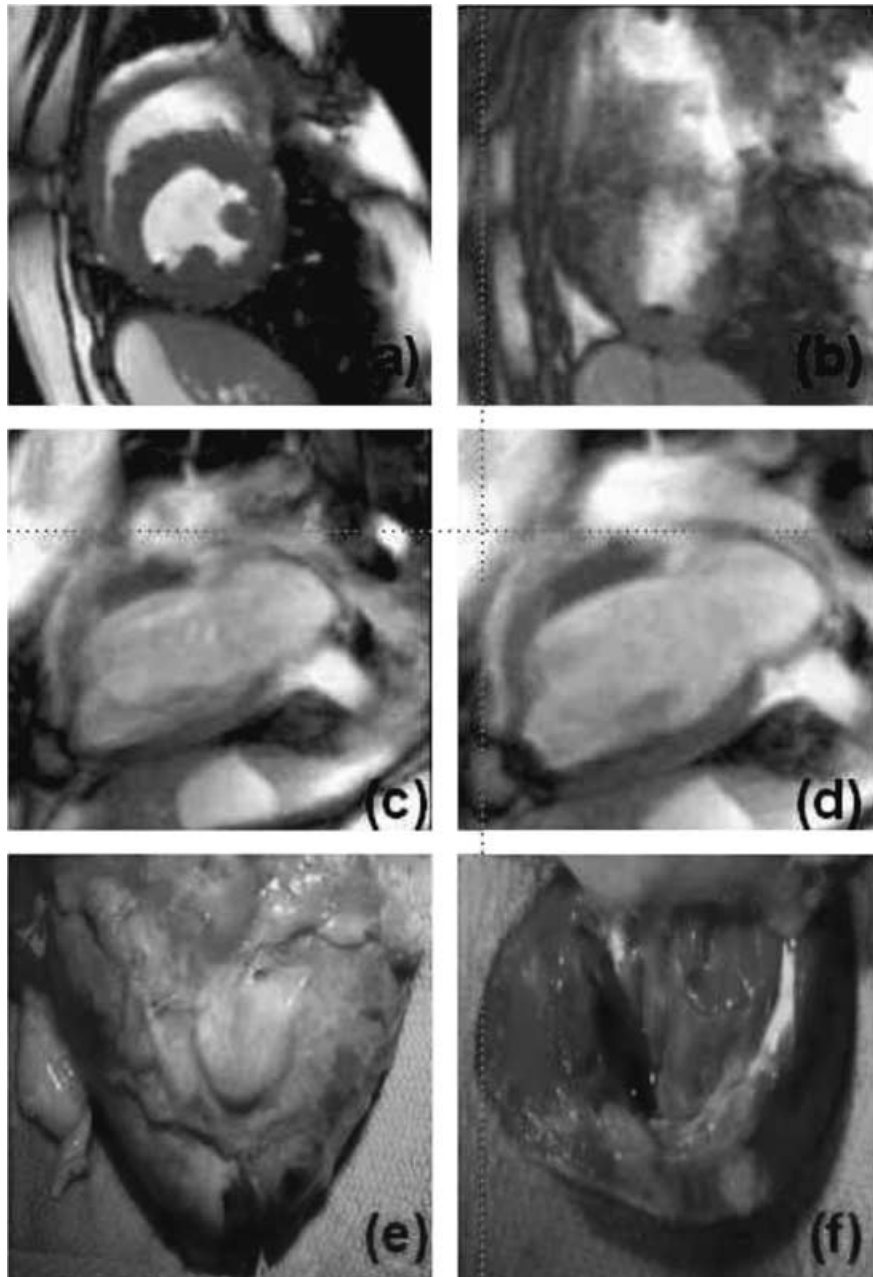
High-resolution T1-weighted short-axis images of catheter position at the papillary muscle (A) and at the apex (B) under real-time fluoroscopy. Long-axis images for pre- (C) and postinjection (D). Postmortem examination of the heart showing the apex (E). The endocardial injected blue dye is also visible on the epicardial surface (F).
